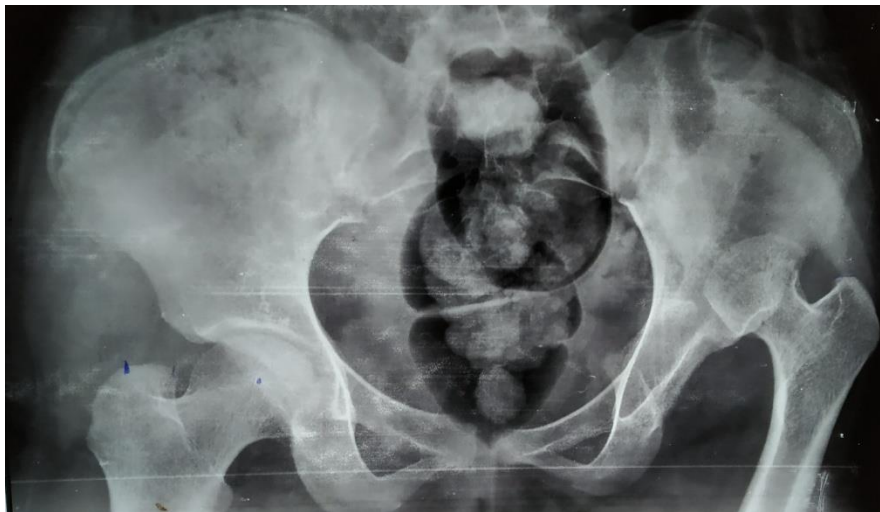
Pre-operative x-ray of the pelvis, showing neglected left posterior hip dislocation.
